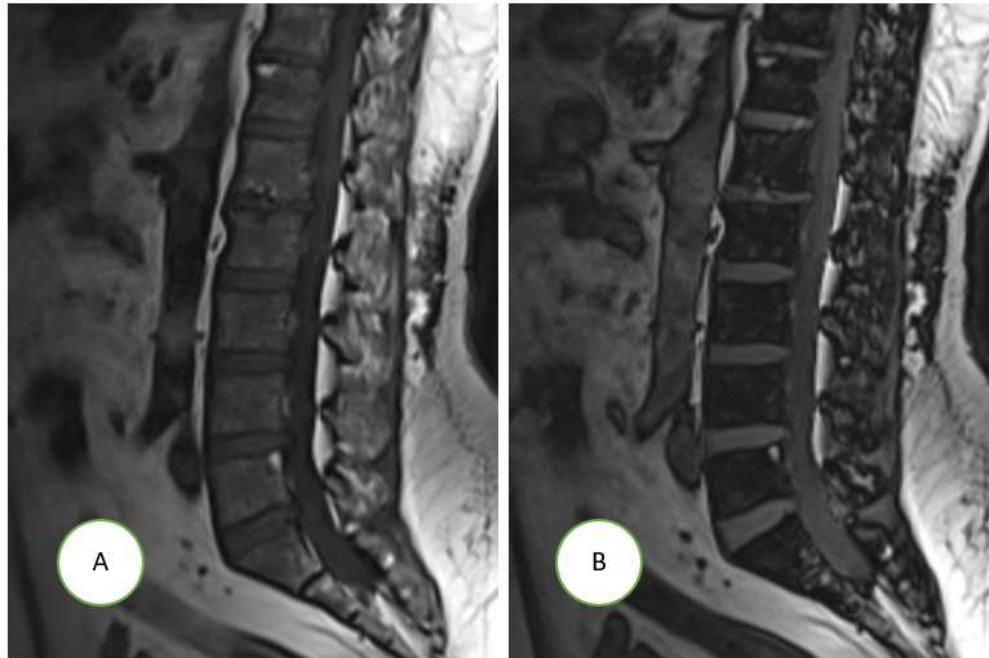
Sagittal MRI of the lumbosacral spine of a 63-year-old man. A) IP Dixon image shows diffuse intermediate marrow SI due to hyperplastic red marrow B) OP image shows a profound reduction of marrow SI owing to its high fat content. % drop ranging from 65 to 75% consistent with benign marrow process)
